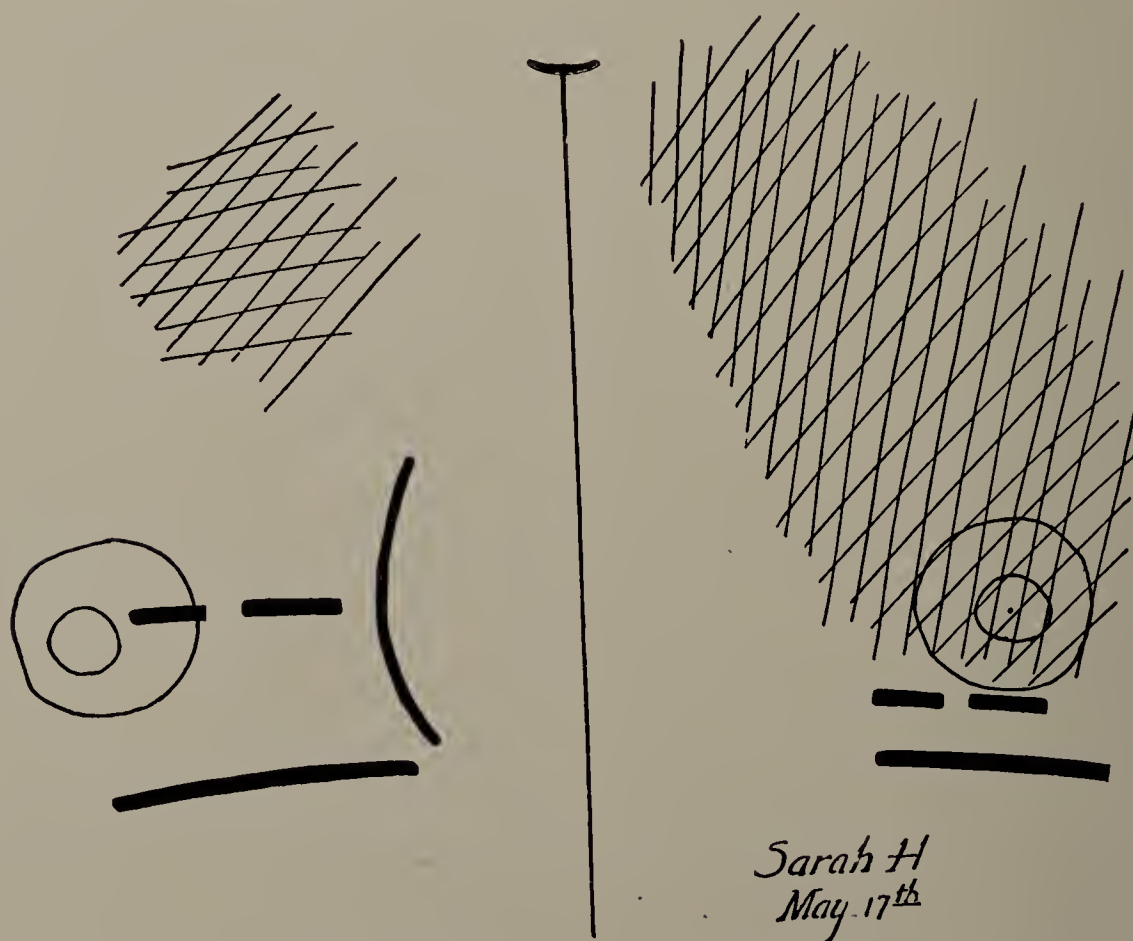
Sarah H. May 17. Fourth X-ray tracing. Excursion of diaphragm 1.25 centimetres on left side; 3.7 centimetres on right side. (One-third life size.)
